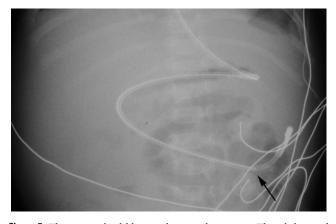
Three-month-old boy with normal anatomy. This abdominal radiograph was obtained to assess feeding tube placement. A wire is present in the feeding tube, stiffening it. As a result, the distal duode-num appears low in position. Arrow, tip of wire in feeding tube.
